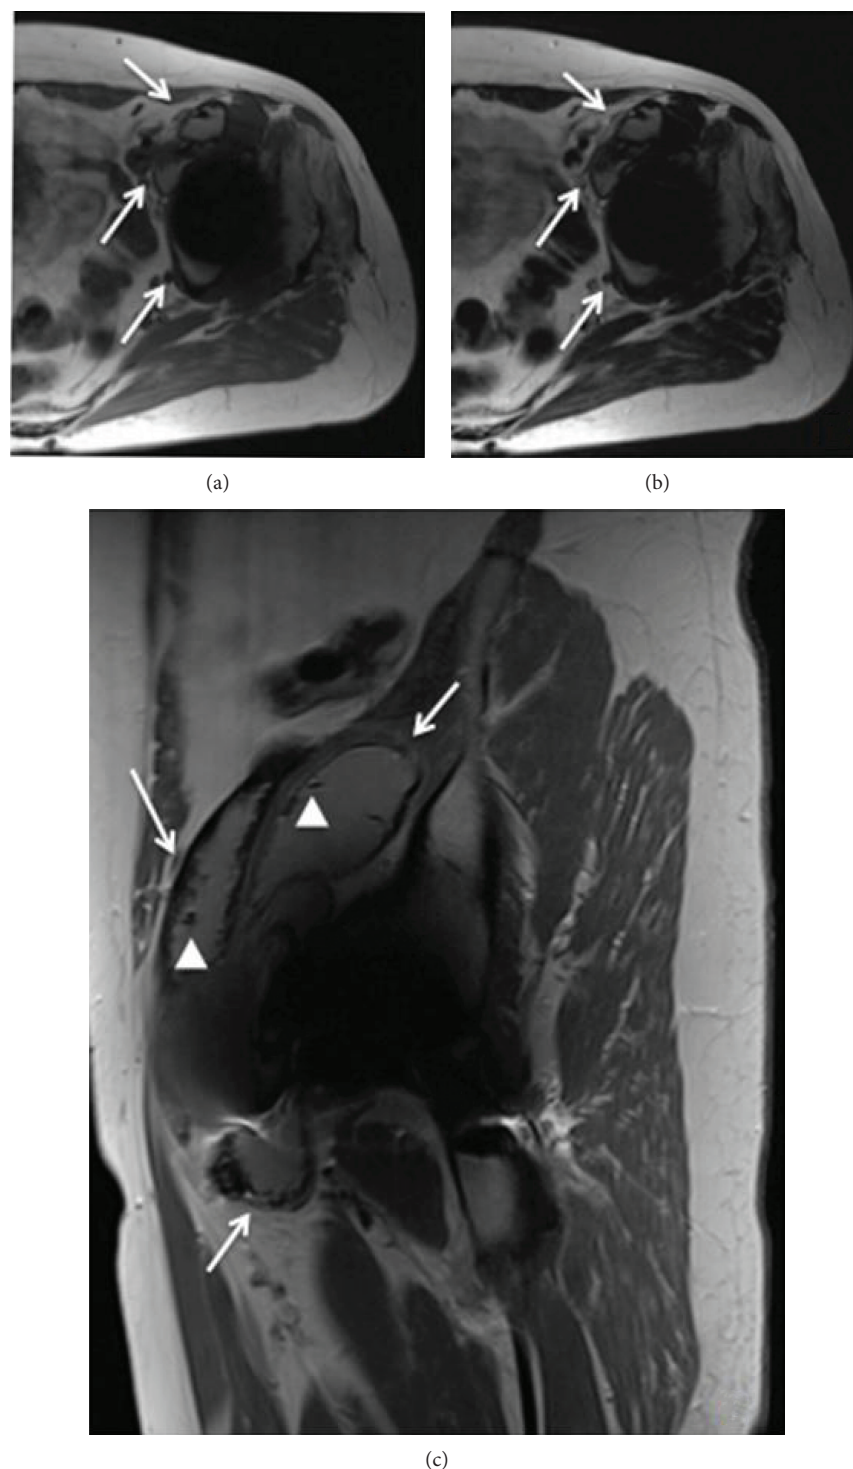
In the metal artefact reduction sequence magnetic resonance imaging (MARS MRI), axial T1 (a), axial T2 (b), and sagittal T1 (c) show the presence of two lesions of thick walls located anterior to the psoas and iliacus (arrows) muscle. Within the lesion, a small focus of artefact is seen (arrow heads). This finding is critical to determining that the aetiology of the pseudotumour is “metallosis.”
